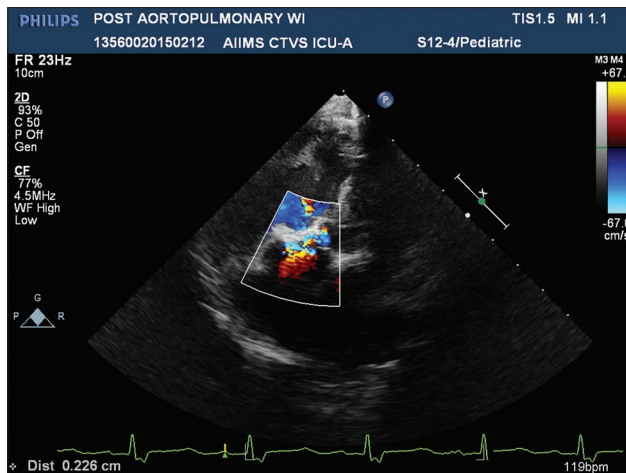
Transthoracic echocardiographic image showing aortic regurgitation jet hitting the Dacron patch used for ventricular septal defect closure
